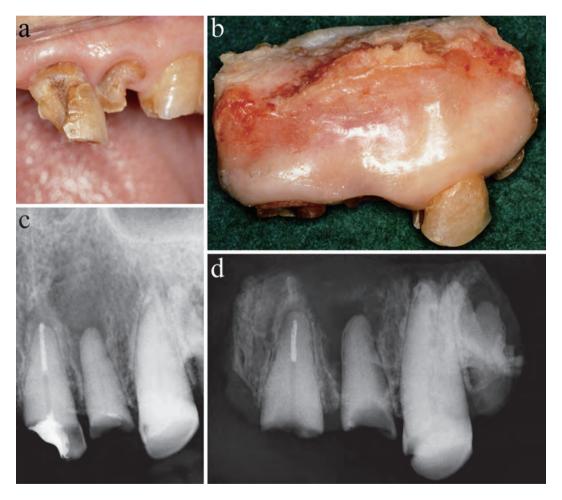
Intraoral photograph of left central incisor (a), Radiograph after filling (b), Resected material (c), and Radiograph of resected material showing a small amount of filling material has disappeared (arrow) from the apical region of the root canal (d).
